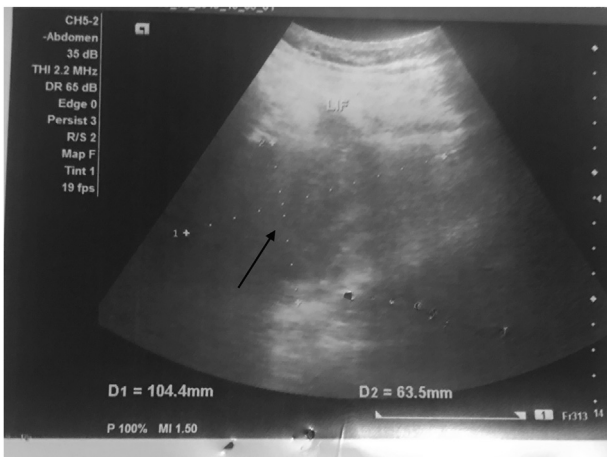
Abdominal ultrasound. Black arrow, showing a left iliac fossa mass/collection 104x64 millimetres non vascular.
